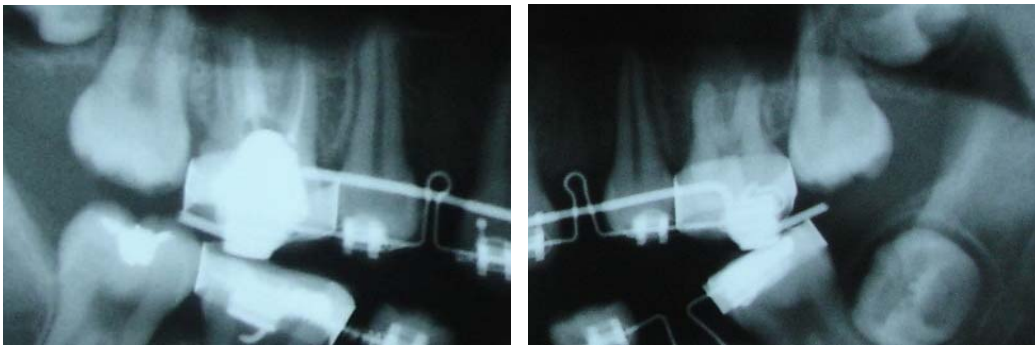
Case1: Radiographs showing improvement in molar tipping by distal uprighting with the use of appliance.
